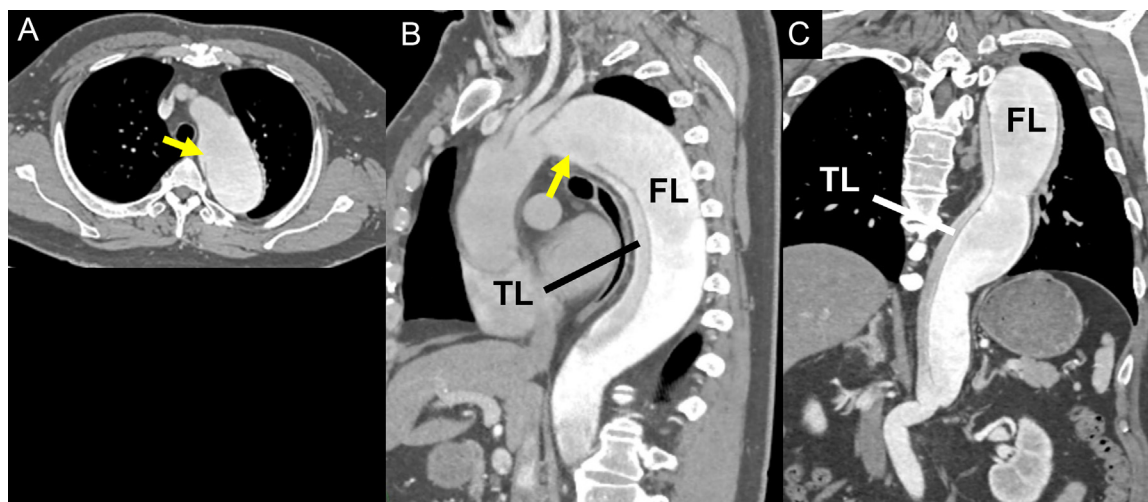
Axial (A) and MPR (B, C) CT images of the chronic aortic dissection. An axial image (A) and oblique sagittal MPR image (B) show the large 40 mm entry at the proximal descending aorta (yellow arrows). A coronal MPR image (C) shows a dilated false lumen (FL), low contrast effect in the true lumen (TL), dilated descending aorta of 62 mm, and re-entry at the level of the celiac artery.
